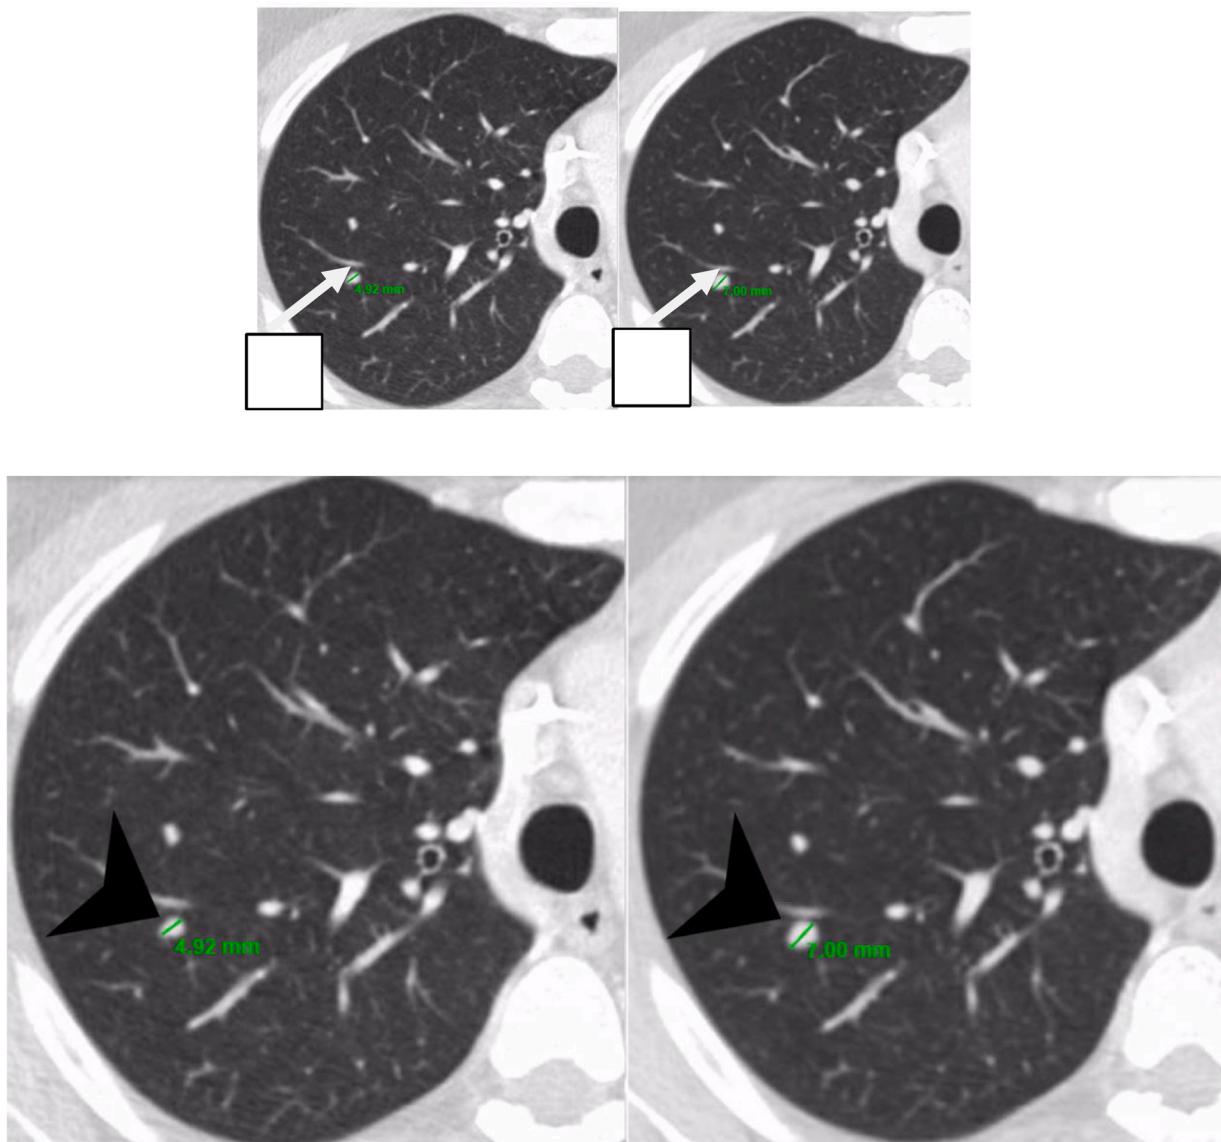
Non-enhanced chest CT, axial view, lung window, of the right upper lobe in a 28-year-old patient diagnosed with rectal adenocarcinoma. In 4 months, a PN (arrows) detected in a follow-up scan grew from 4.9 mm (A) to 7.0 mm (B), an increase of <50 %.
